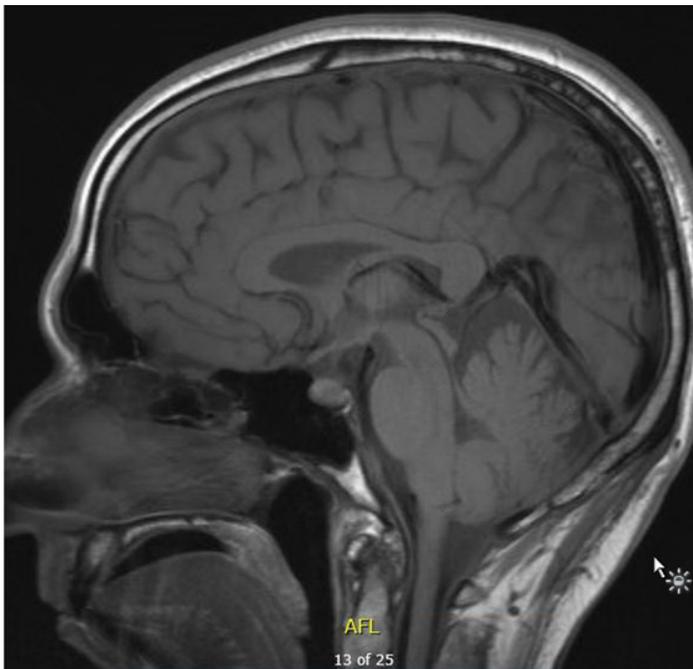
Brain MRI on Initial presentation: Diffuse, smooth pachymeningeal enhancement consistent with intracranial hypotension on T2 weighted image.
